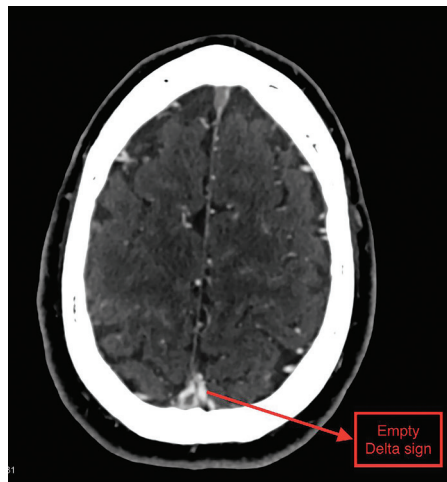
Contrast-enhanced computed tomography with empty delta sign labelled.
